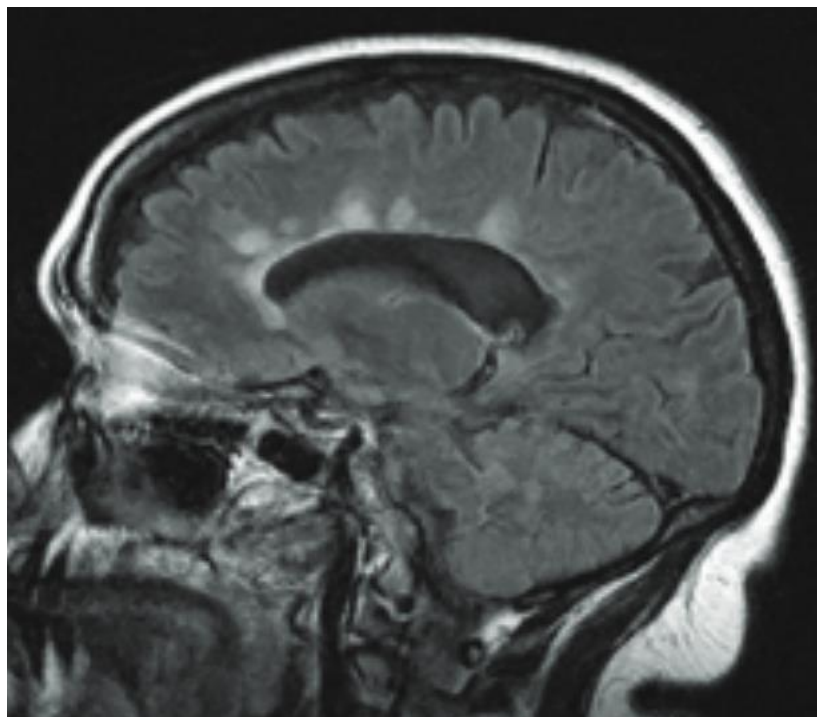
Dawson fingers lesions on a sagittal fluid-attenuation inversion recovery (FLAIR) MRI. Finger-like projections found perpendicularly to the lateral ventricles, are MS-specific ⁴⁴⁹.
